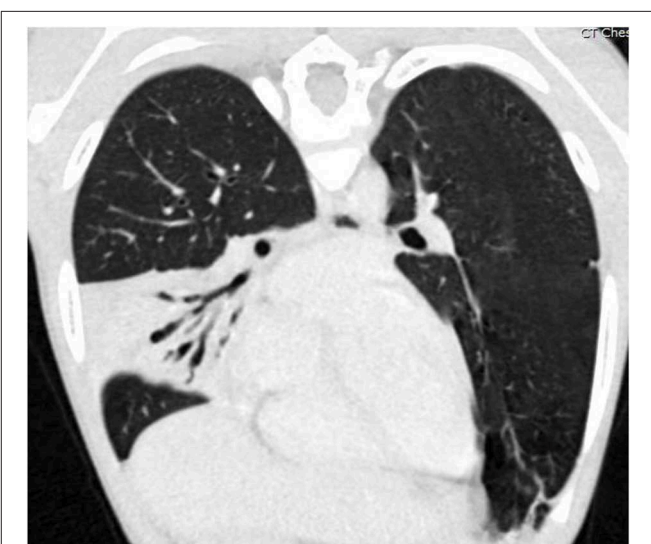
Coronal oblique reformatted CT image of the chest of the same patient as Figure 3, demonstrating air bronchograms within a right middle lobe consolidation with varicose bronchiectasis. Image courtesy David A. Manning, MD, Radiologist, Children's Hospital New Orleans.
